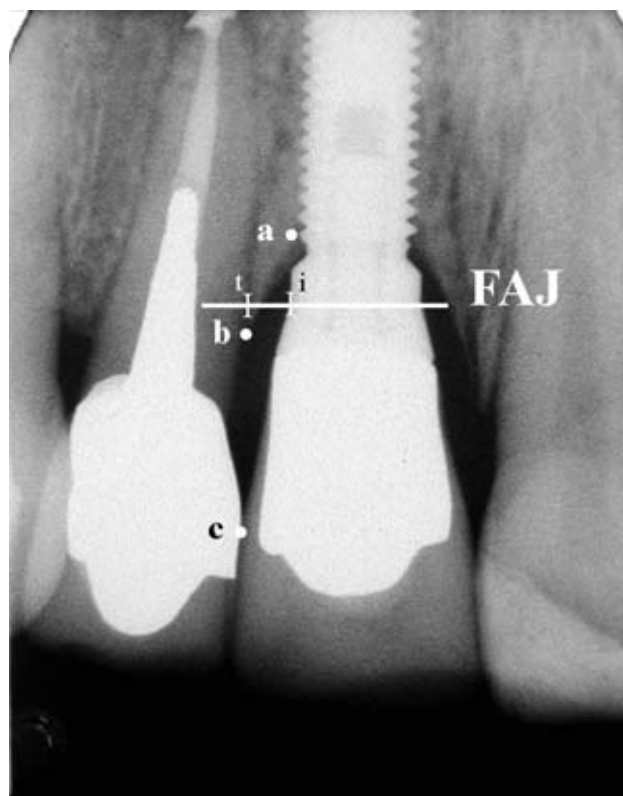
Radiograph showing the selected reference level (fixture/abutment junction [FAJ]) and the selected measuring points (see text).
